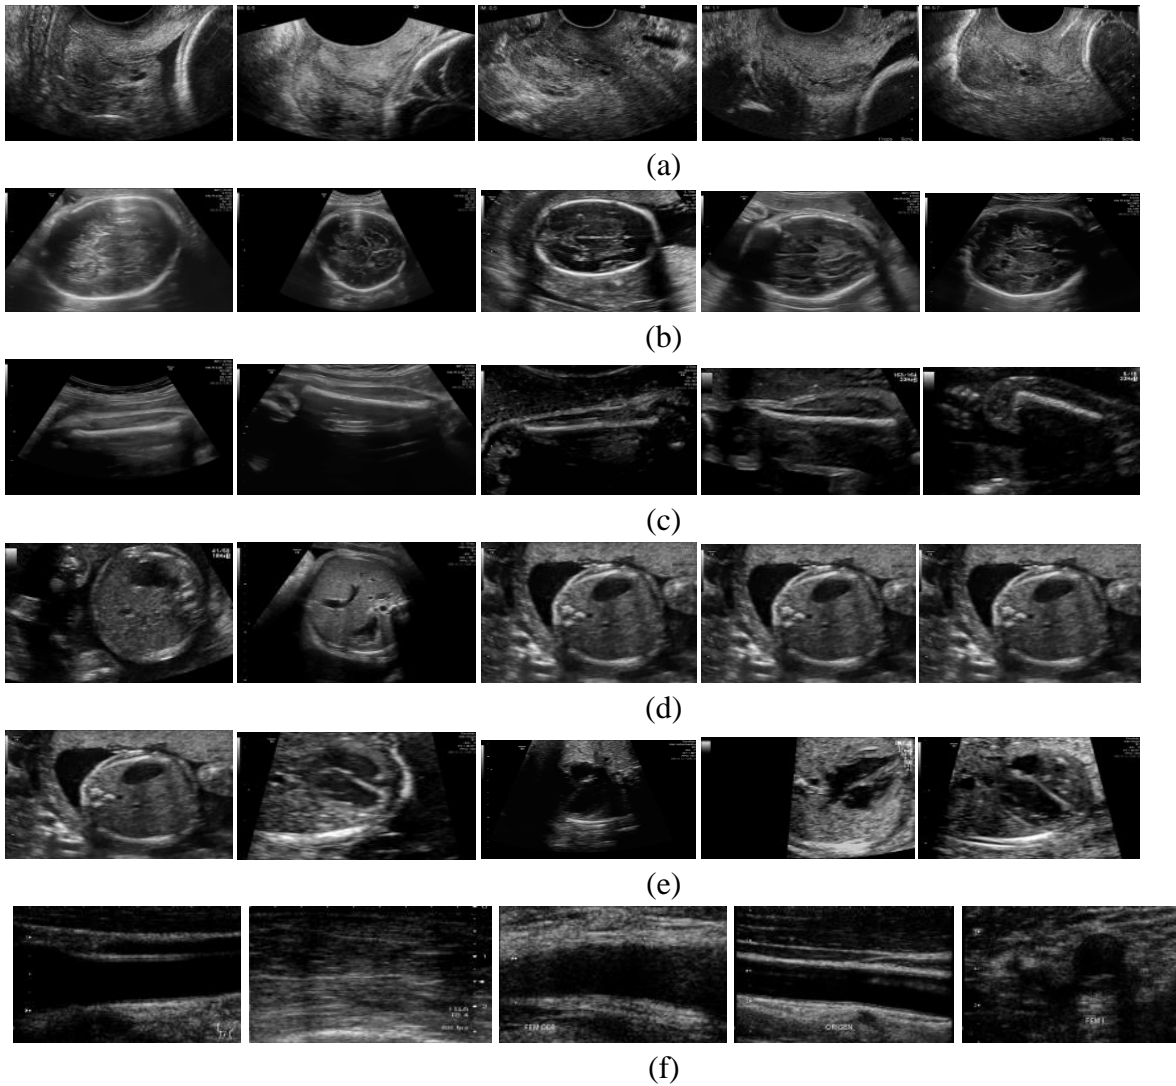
Sample images from the fetal ultrasound Doppler scan images (a) Maternal Cervix (b) Fetal brain (c) Fetal femur (d) Fetal Abdomen (e) Fetal thorax (f) Others
